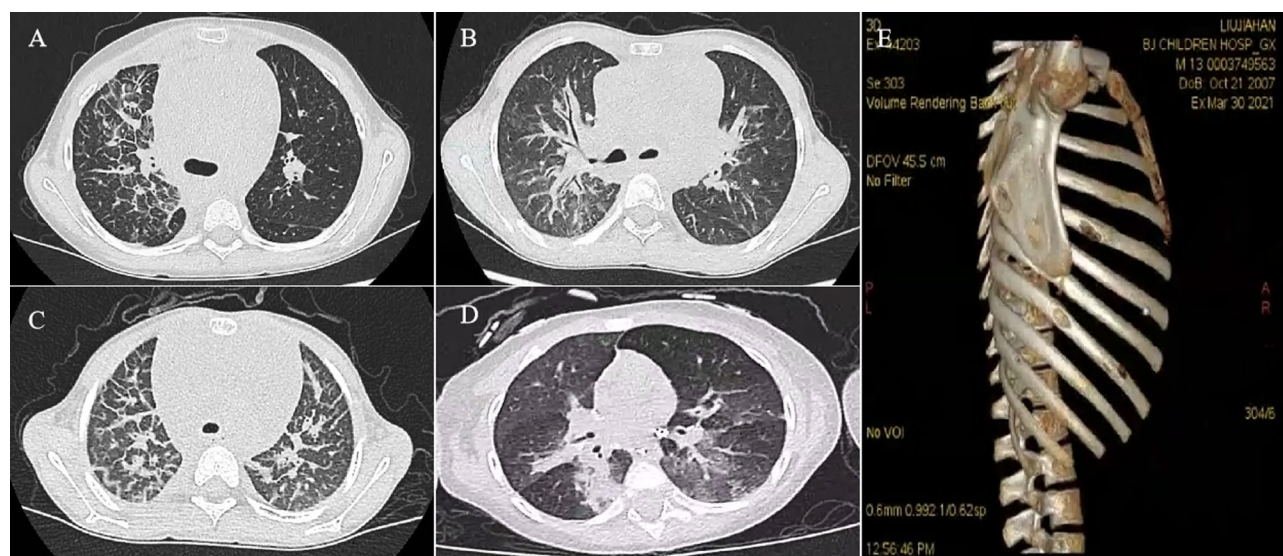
Radiographic findings of chest high-resolution computed tomography (HRCT) in patients with CLAs. (A) In a patient with KLA, HRCT shows interlobular septal thickening of the right lung. (B) In a patient with GLA, HRCT shows diffuse mediastinal lesions involving the lung hilum and bilateral bronchial wall thickening. (C) In a patient with GLA, who had a 7-year medical history prior to treatment, HRCT shows thickening of the interlobular septum and pleura in both lungs. (D) In a patient with CCLA, a bronchial cast was removed by bronchoscopy. HRCT shows multiple ground-glass opacities in both lungs and an increased density in the right bronchus with distal truncation. (E) For a patient with GSD, CT bone reconstruction reveals multiple areas of bone destruction in the ribs and scapula
